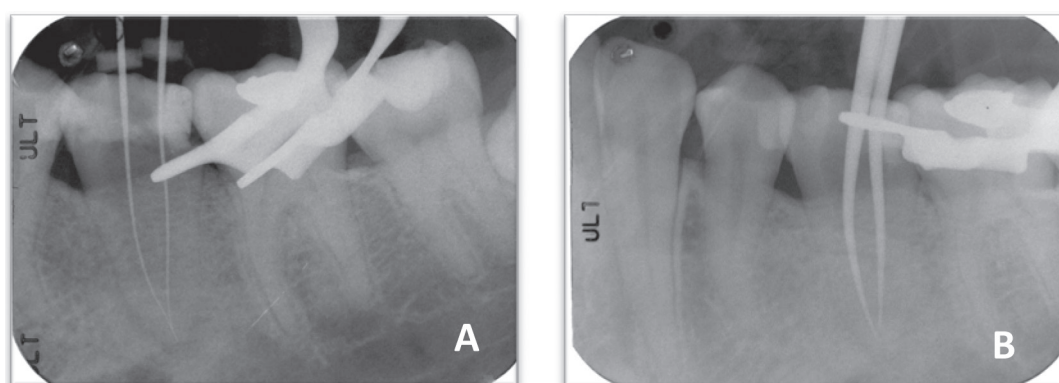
A- Radiographic image of working length determination. Mesial and distal canals were joined at the 2-mm level from the working length. B- Radiographic image of the two greater-taper main cones within the prepared canals (25/.06 for mesial canal and 30/.06 for distal canal) after mechanical instrumentation of the canals with the rotary Ni-Ti files.
